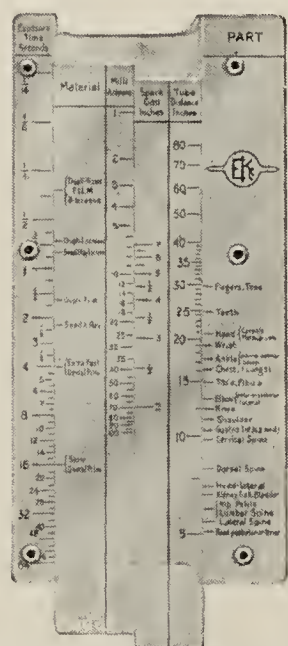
SLIDE RULE FOR CALCULATING X-RAY EXPOSURES.
